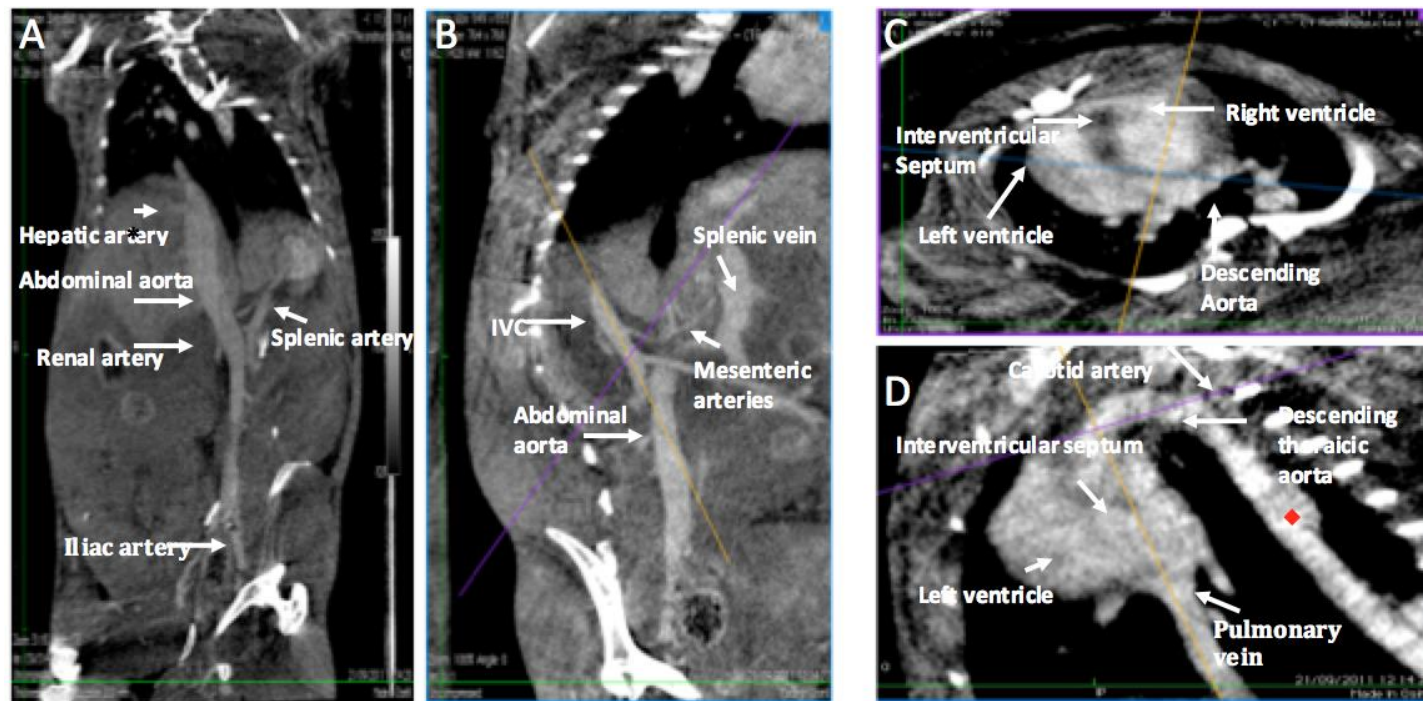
Contrast CT scan performed 60mins after intravenous blood pool agent ExiTron nano 12000
